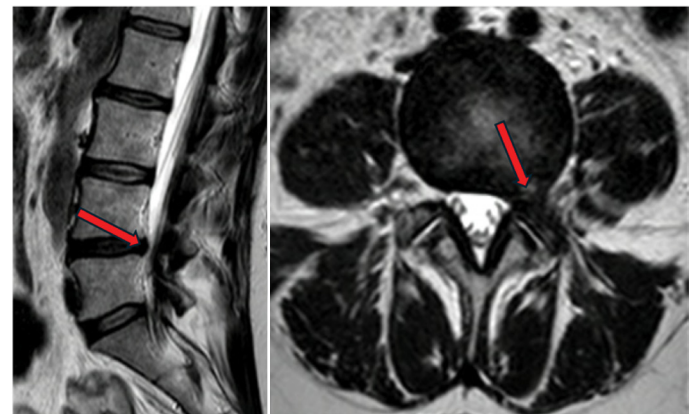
Sagittal and axial MRI cuts showing recurrence of left L4-L5 foraminal hernia (arrow).
